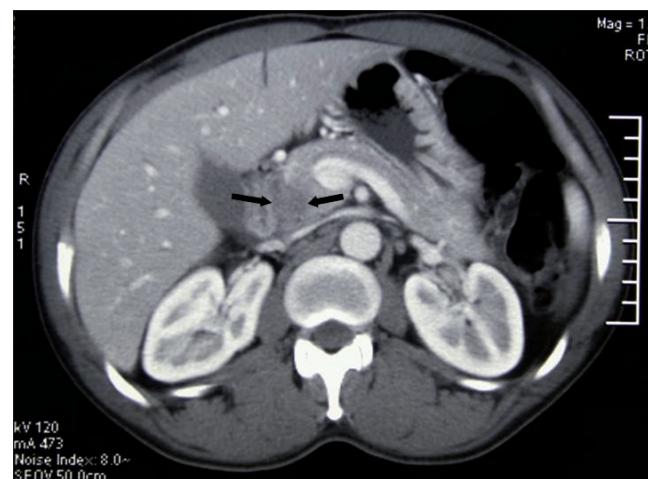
CT scan image demonstrating a 3x2 cm hypodense lesion in the head of the pancreas suggesting pathology other than adenocarcinoma of the pancreas.
